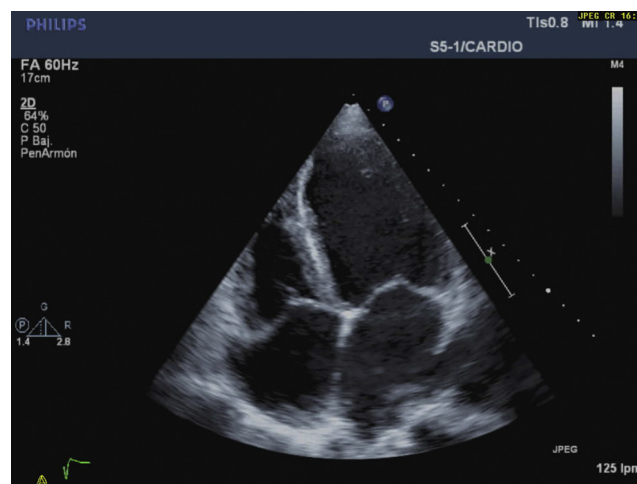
Preoperative transthoracic echo. Ejection fraction of 20%.
